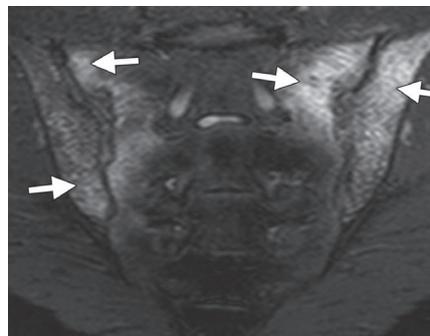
Coronal oblique fat-suppressed T2-w MR image of the sacroiliac joints in a patient with ankylosing spondylitis shows bilateral periarticular bone marrow edema (arrows).
